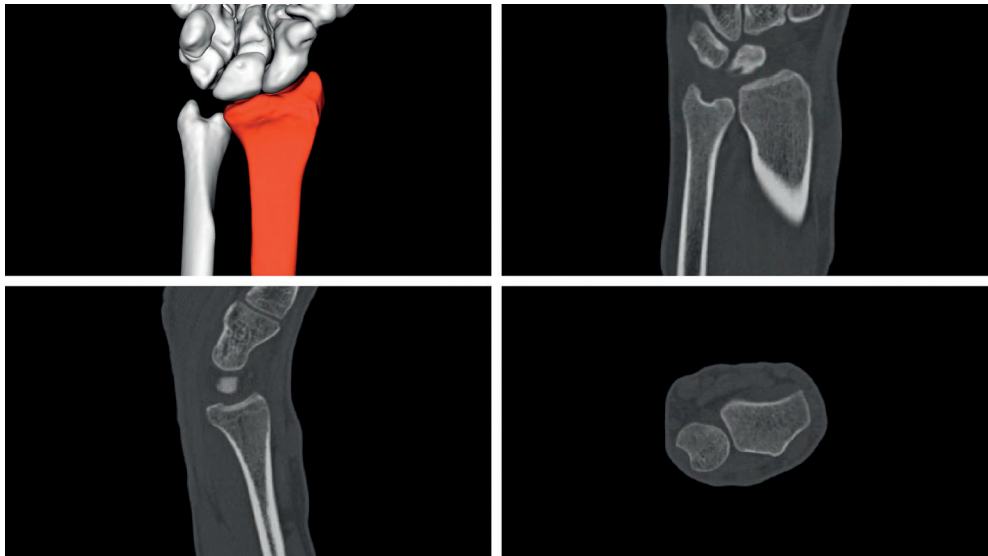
CT scan of the wrist showing slices in the coronal (top right), sagittal (bottom left), and axial (bottom right) planes. A 3D representation can be visualized after segmentation (top left).
